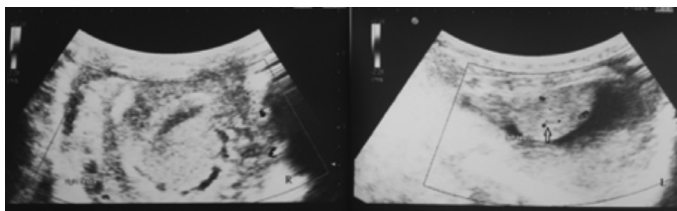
Colour Doppler ultrasonography revealed that the testis was heterogeneous in appearance and its size was significantly increased compared to the symmetry. Unlike the left testis, no blood flow was observed in the right testis (arrow shows the vascular coding in right testis)
